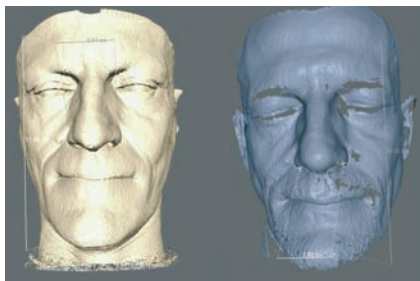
Some inter-landmarks distances identified on the 3D reconstruction both obtained by CT (left) and by white-light scanning (right) on the same patient.
